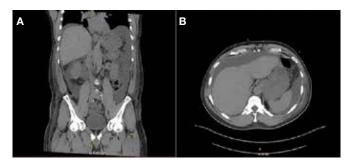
Computed tomography of the abdomen and pelvis demonstrating undulation of the liver contour with moderate abdominal and pelvic ascites and anasarca. A, coronal plane; B, axial plane.
